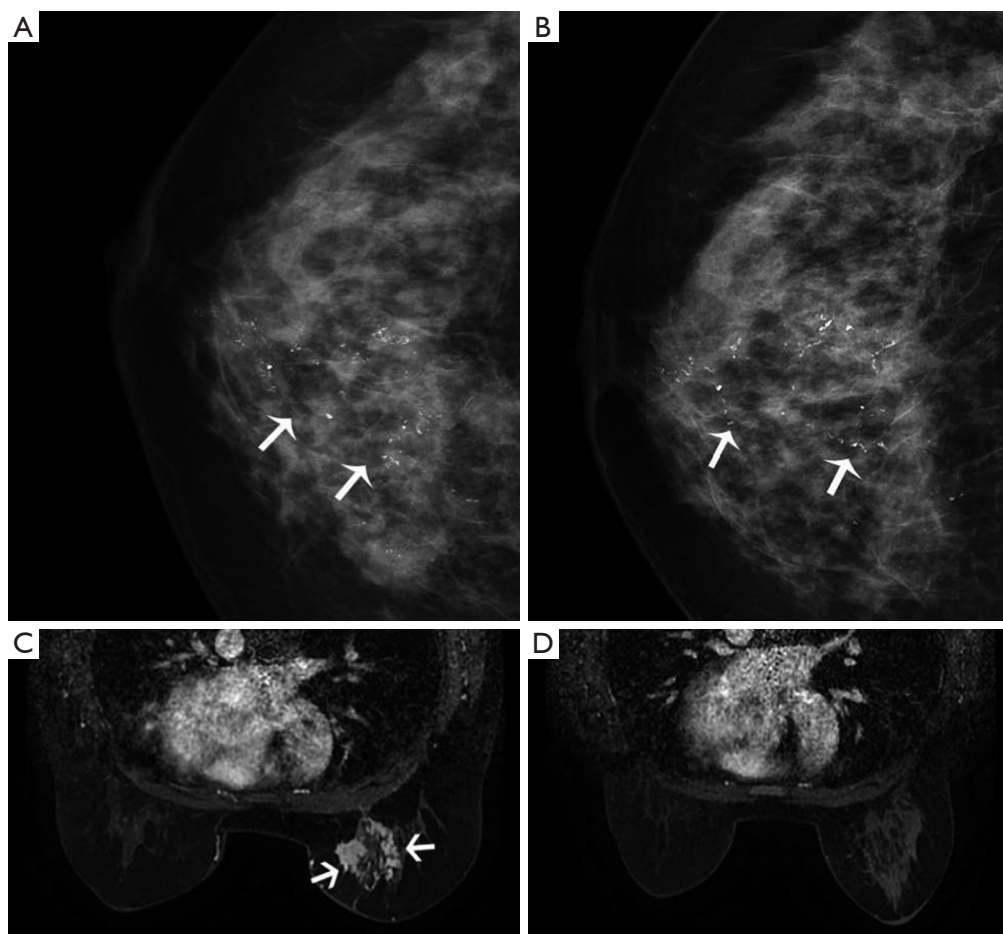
Imaging of a 52-year-old woman with invasive ductal carcinoma. (A) Mammogram showing fine linear segmental calcifications (8.6 cm) in the right upper inner quadrant before NAT (arrows). (B) No obvious changes in the size of calcifications after NAT (arrows). (C) MRI showing multiple enhancing masses in the right breast (arrows). (D) Lesions on MRI disappeared, and final pathology confirmed complete resolution. NAT, neoadjuvant treatment; MRI, magnetic resonance imaging.
